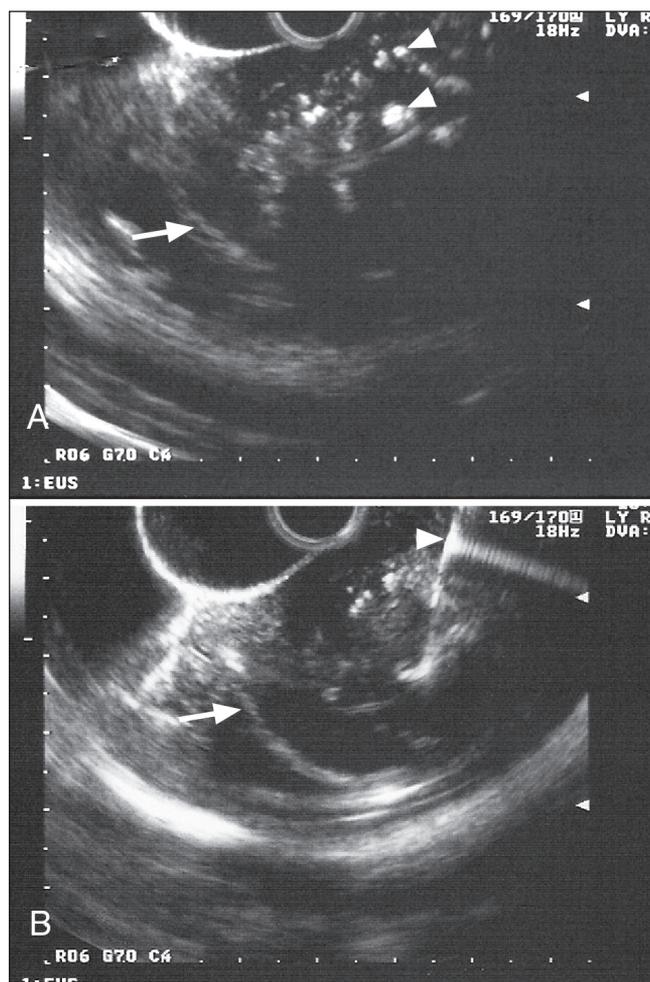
Endoscopic ultrasound image of a patient with a diffuse hypoechoic irregular pancreatic head and the coexisting diagnosis of chronic pancreatitis (arrows identify suspected mass; arrowheads identify calcifications seen in chronic pancreatitis). A Fine-needle aspiration (FNA) was performed given the difficulty in ruling out the presence of an underlying mass. B The FNA diagnosis was negative and the patient is cancer-free at two years follow-up
